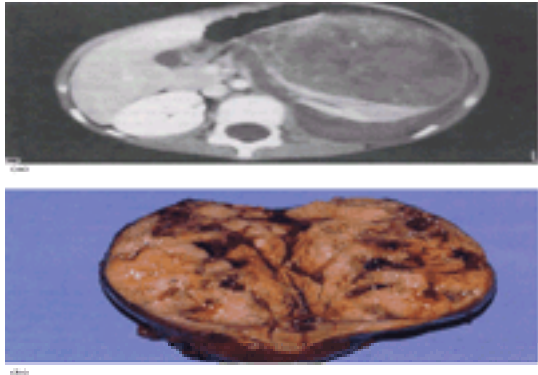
(a) Computed tomogram of a 5-year-old girl with a large anaplastic Wilms tumor reveals the thin capsule of normal renal parenchyma surrounding the primary tumor. There is also extension of the tumor into the retroperitoneal tissues posterior to the kidney. (b) Transected Wilms tumor demonstrates margin of normal parenchyma and the characteristic heterogeneous Wilms tumor.
